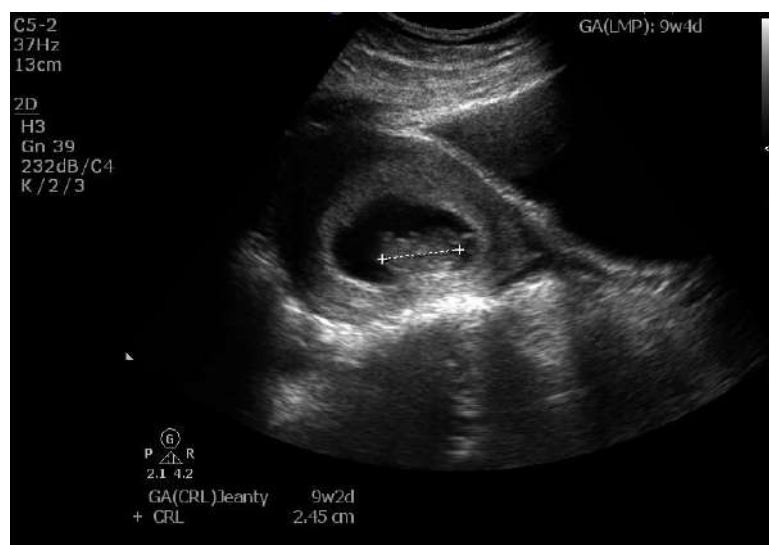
Real-time ultrasound showing measurement of crown-rump length (CRL) of 2.45 cm by placing one point on the head and the other on the rump.
